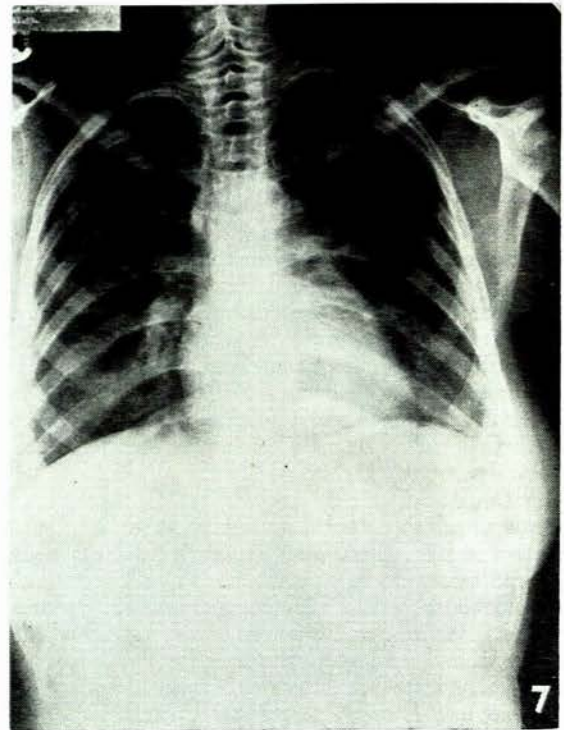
Follow-up X-ray of chest after steroid therapy—case 5. (Note the radiologically apparent increase in total volume as compared to Fig. 5.)
